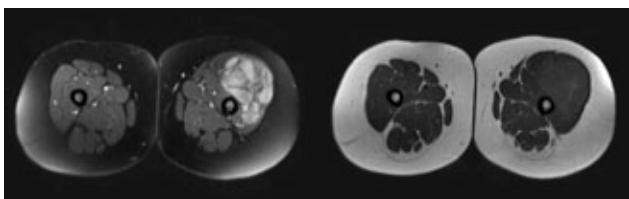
Magnetic resonance imaging of pleomorphic rhabdomyosarcoma in the anterior compartment of the thigh.
